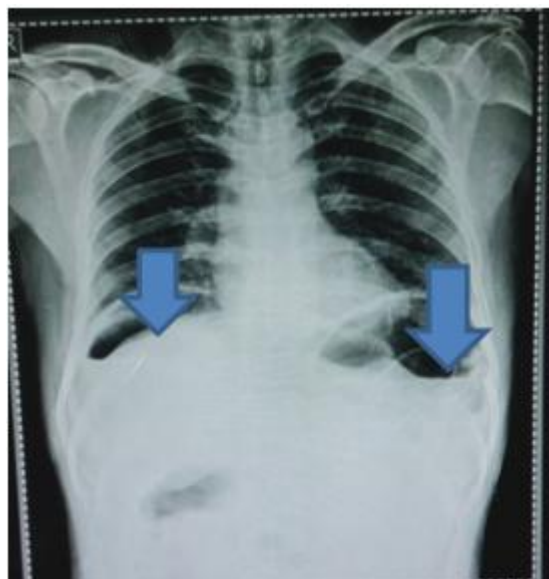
Plain erect abdomen xray showing Chilaiditi sign done on first day of presentation
